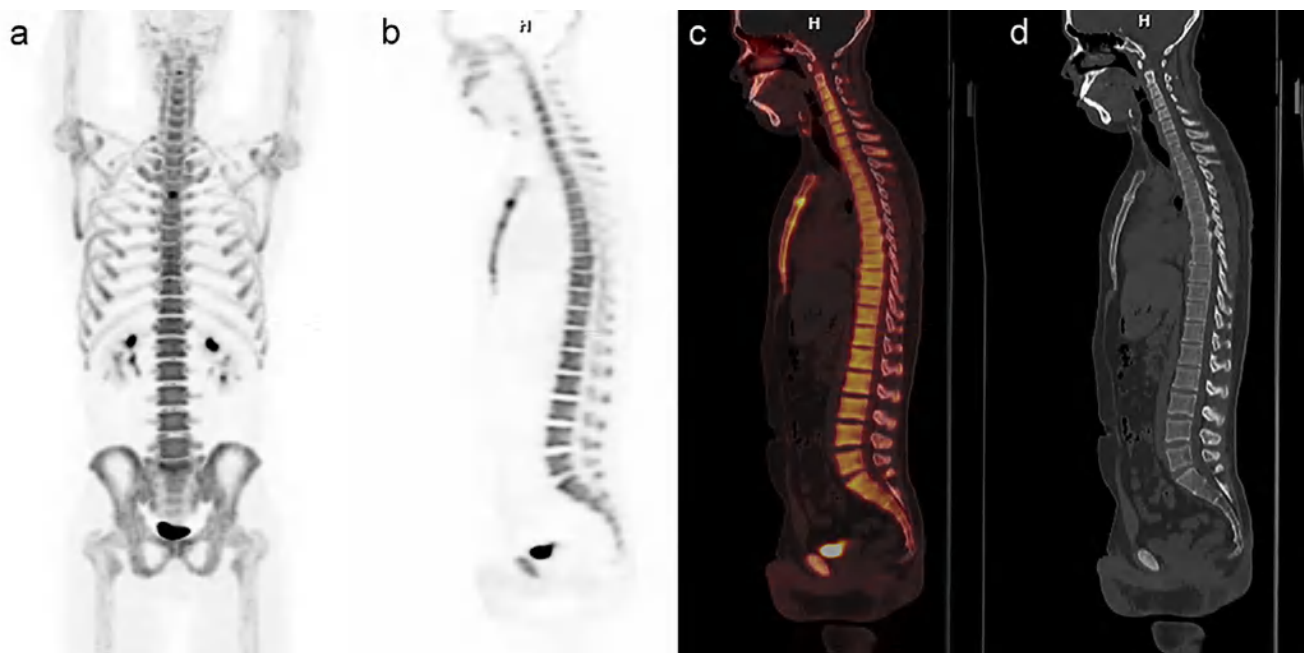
$^{18}\text{F}$ -NaF positron emission tomography image of a 29-year-old patient with chronic lower back pain who tested negative for serological human leukocyte antigen B27 and did not meet the Assessment of SpondyloArthritis International Society criteria for ankylosing spondylitis. The maximum intensity projection image (a) and sagittal plane images of both positron emission tomography and nonenhanced computed tomography (b–d) are represented as a normal scan.
